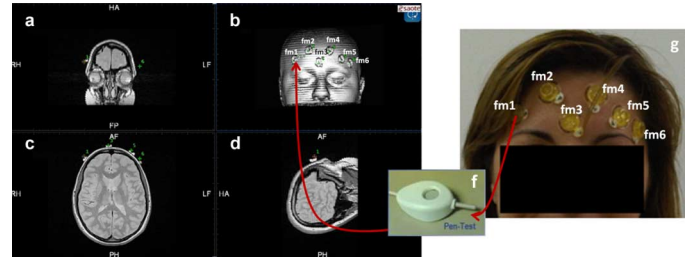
Registration: step 1. First phase: pointing of the corresponding fiducial marker both in the Proton Density MRI 3D rendering (b), with the 3 main planes as reference (coronal -a-, axial -c-, sagittal -d-) and on the subject's forehead (g) laying in the bed before US examination. Registration pen shown in (f).
